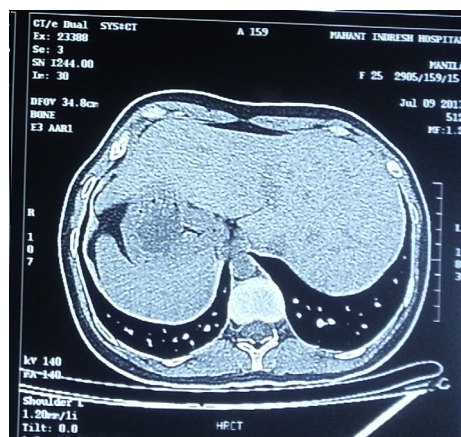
Abdominal cut (CT) shows situs inversus, the liver on the left side and the spleen and the stomach on the right side.
